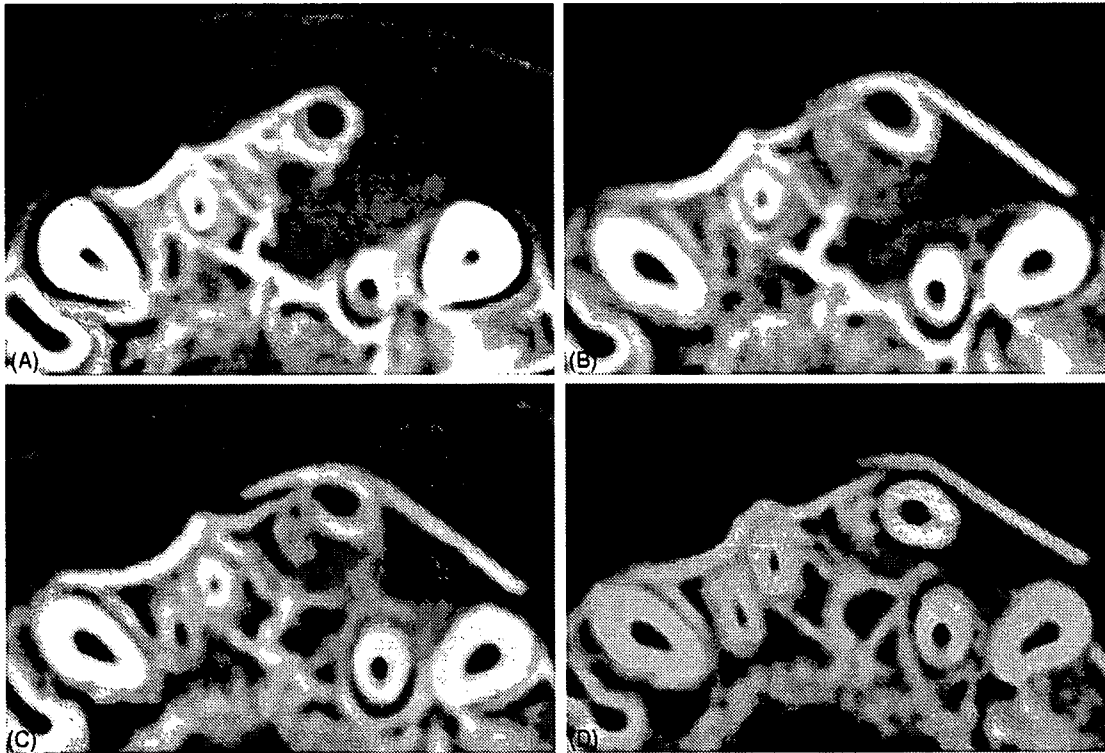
Serial computed tomograms slicing the middle level of the alveolar cleft: (A) preoperation; (B) 3 months postoperation. Dome-shaped radiopaque images facing together and extending from the cleft bony walls inside the cavity (C) 6 months postoperation. Fused image in the cleft cavity and (D) 9 months postoperation. The lateral and supernumerary incisors are approximated in the bony bridge lateral to the reconstructed incisive canal.
